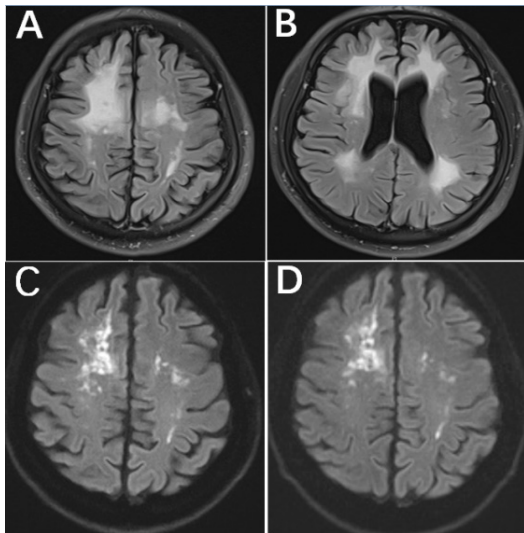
(A). Confluent multiple, patchy white matter lesions in the frontal and parietal lobes on FLAIR. (B). Symmetrical and hyperintense lesions in the periventricular areas on FLAIR. (C). DWI hyperintensities in frontal and parietal lobes in June, 2021. (D). DWI hyperintensities in October, 2021.
